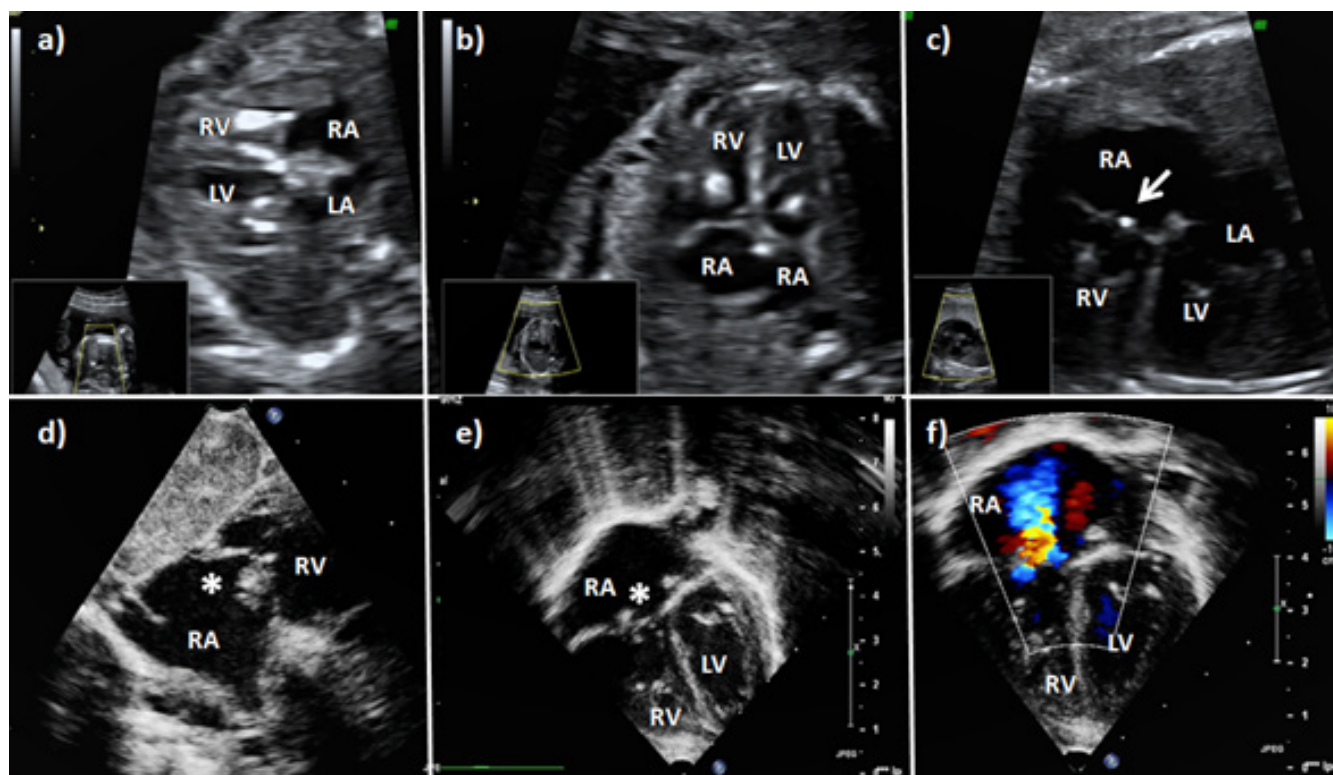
A two-dimensional fetal echocardiogram (a-c) with localized areas of increased echogenicity at the papillary muscles of both AV valves. The last fetal echocardiogram (c) showed minimal residual echo bright density limited to the tricuspid valve (arrow). Postnatal echocardiogram showed the tricuspid valve with an image resembling vegetation (asterisk) and, by color-flow Doppler, severe insufficiency of the tricuspid valve (d-e). RV: right ventricle. RA: right atrium. LV: left ventricle. LA: left atrium.
